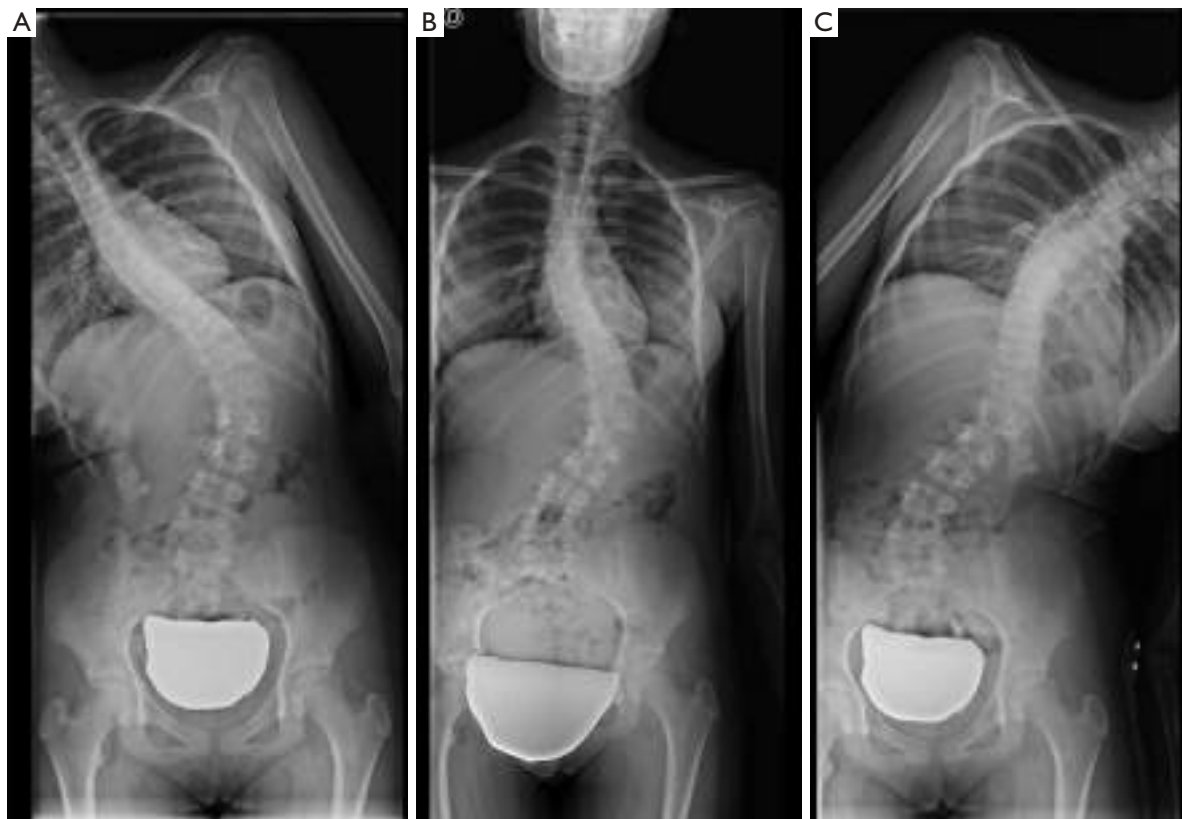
Structural thoracolumbar curve. No significant correction is achieved with bending manoeuvres. (A) Right bending radiograph; (B) AP radiograph; (C) left bending radiograph.
